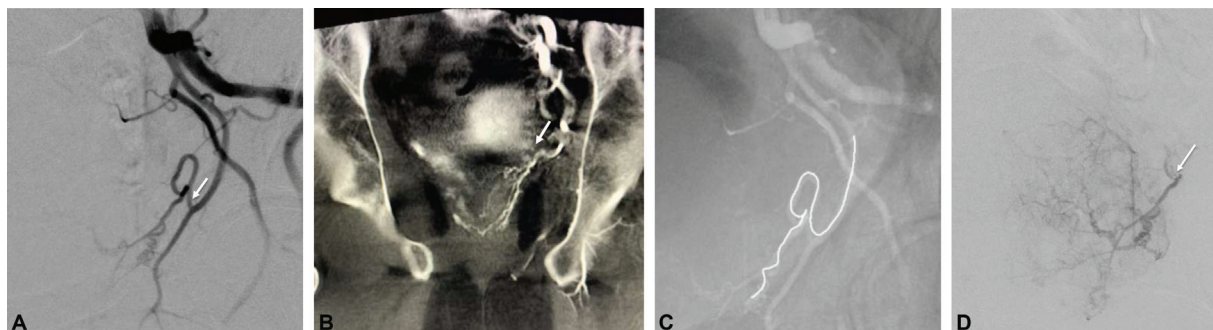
A 77-year-old man with BPH and LUTS for over 10 years, was initially treated medically with dutasteride. However medical management was discontinued due to medication side effects. The patient underwent PAE using CBCT with embolization guidance software navigation (A–D). (A) Diagnostic angiography of the left internal iliac artery demonstrating the left prostatic artery (arrow) apparently arising from the inferior vesical artery. (B) Coronal reconstruction cone beam CT demonstrating the origin of the left prostatic artery (arrow) arising from the inferior vesical artery. (C) Automatic vessel detection using Syngo Embolization Guidance software reconstructing left prostatic artery virtual image for overlay with 2D live fluoroscopy. (D) Successful catheterization and selective angiography of the left prostatic artery (arrow).
